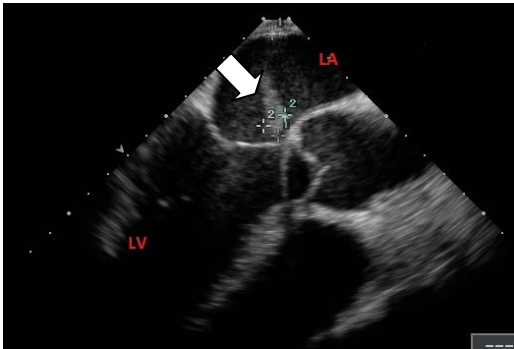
A transesophageal echo showed a 3.7 cm long mobile thrombus attached to the roof of the left atrium (arrow), LA: left atrium, LV: left ventricle.
